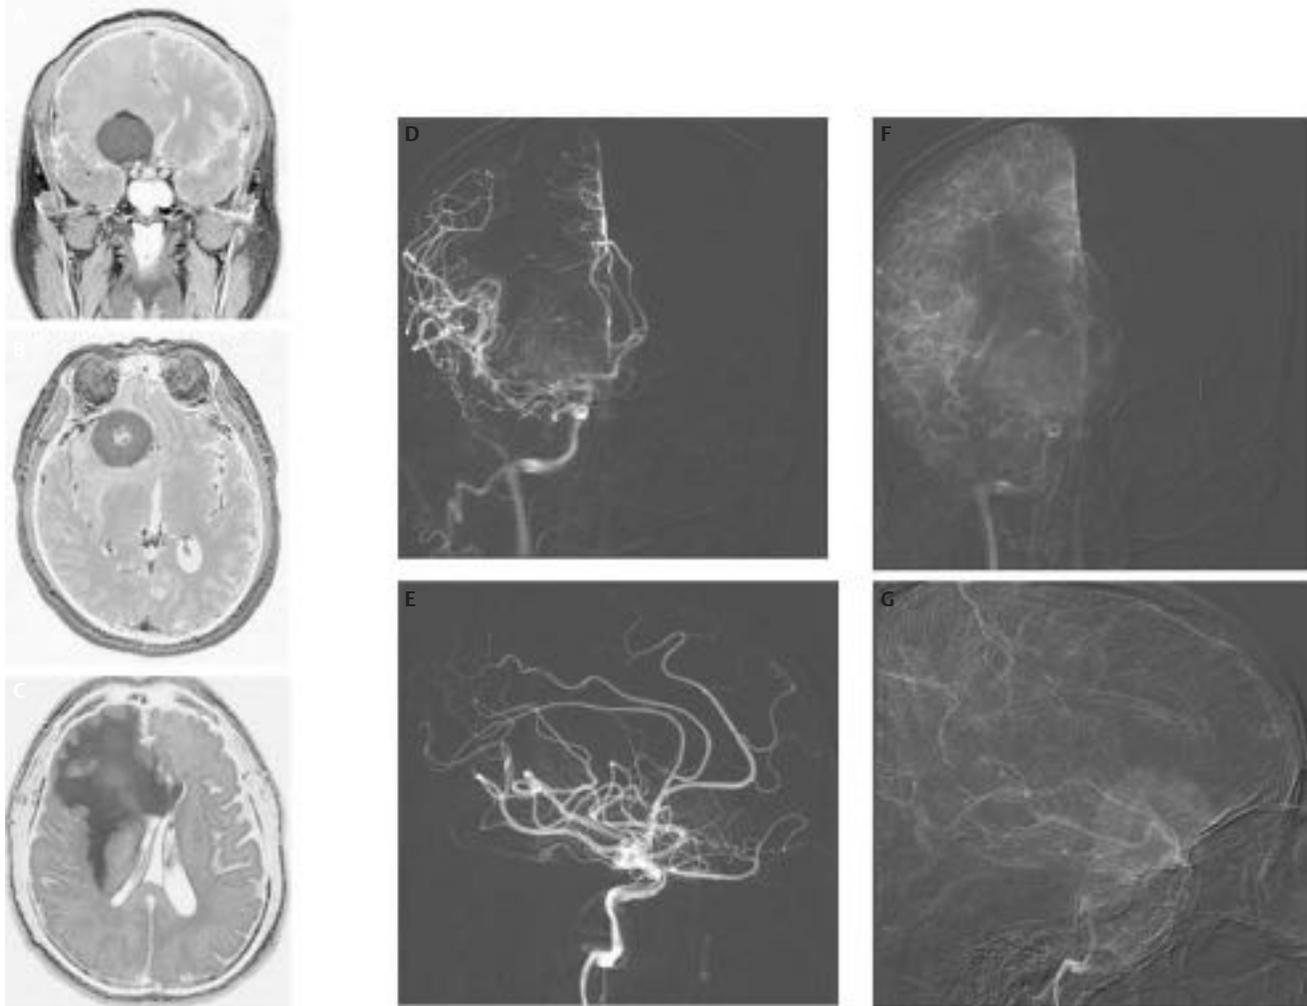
Right anterior paraclinoid meningioma. (A) Coronal and (B) axial magnetic resonance imaging (MRI) demonstrating a homogeneously enhancing mass with central necrosis. (C) Axial fluid-attenuated inversion recovery MRI demonstrating a vast amount of edema, often evident with pial vascular supply. (D,F) AP and (E,G) lateral, (D,E) arterial and (F,G) venous phase left internal carotid artery angiograms demonstrating extensive ophthalmic and anterior cerebral artery supply to the hypervascular tumor blush centered in the anterior cranial fossa. Significant mass effect is noted on the anterior cerebral arteries below the level of the falx cerebri. Due to the extensive pial vascular supply to this tumor, preoperative embolization was not undertaken.
